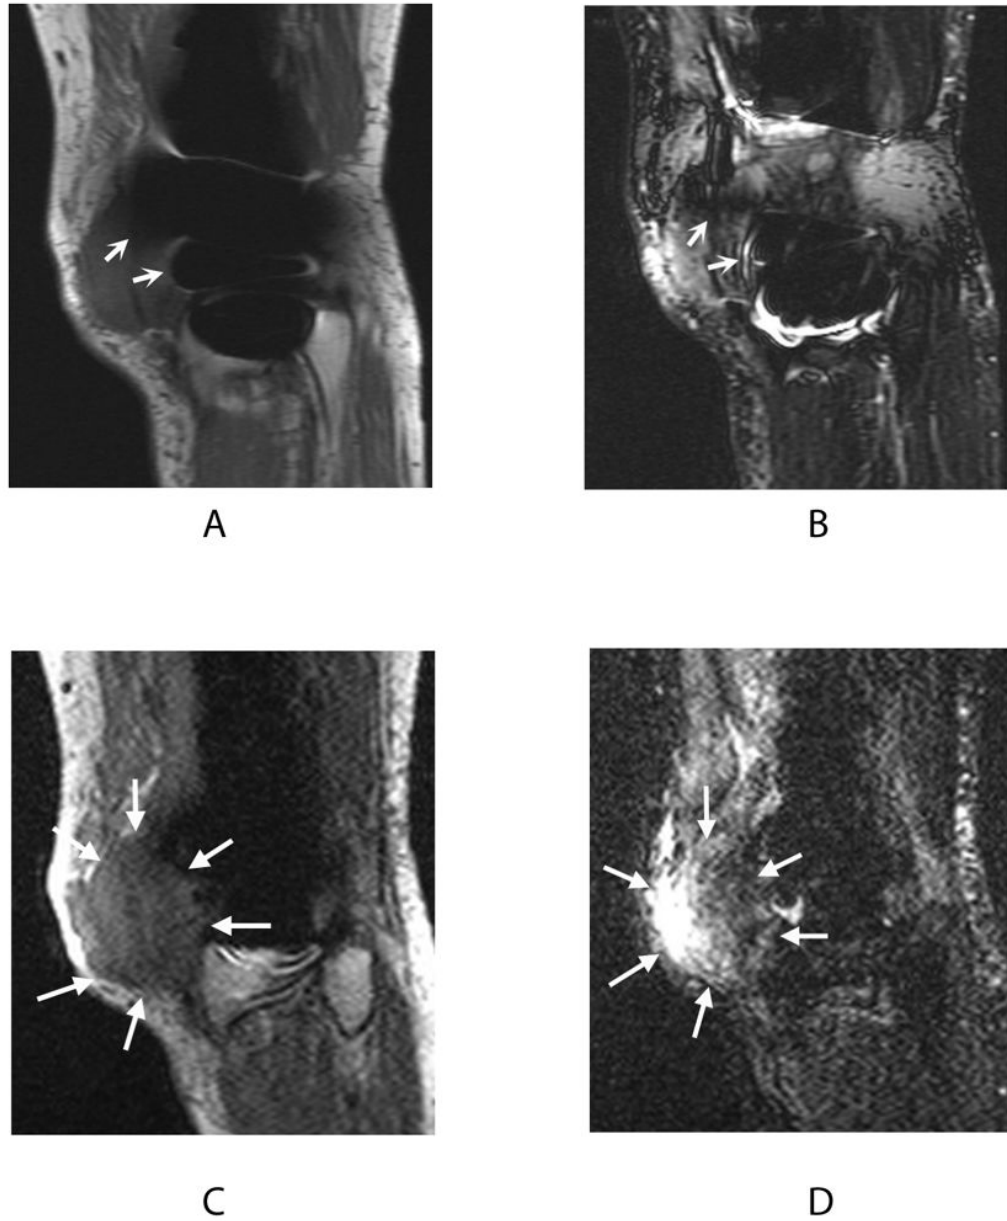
Signal loss in 2D-FSE PD (a) and 2D-FSE IR (b) images (*curved arrows*) obscures the full extent of recurrent osteosarcoma visible on PD-SEMAC (c) and IR-SEMAC (d) images (*wedge-shaped arrows*). This finding on SEMAC images led to computed tomography (CT) scanning for lung metastases, confirmed at biopsy.
